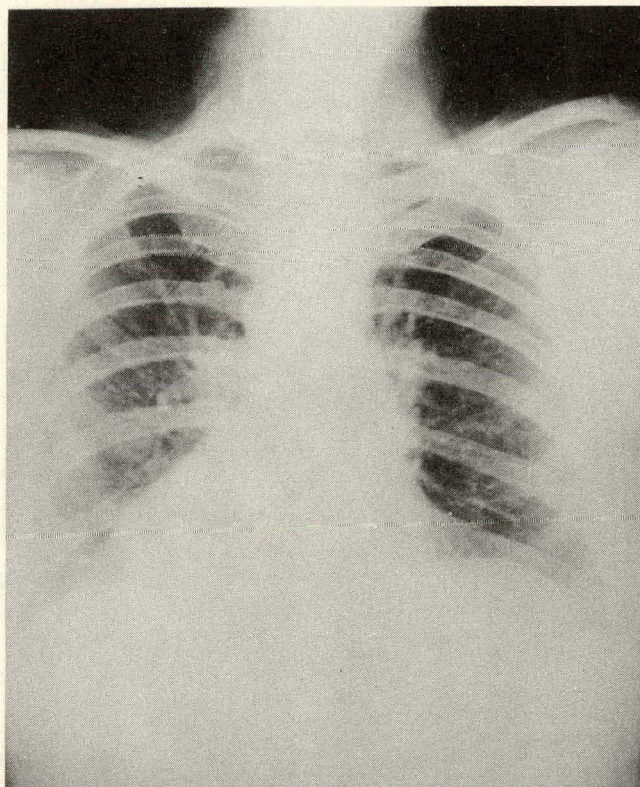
Roentgenograph of chest. Mediastinal masses have disappeared. Trachea is almost in midline.
